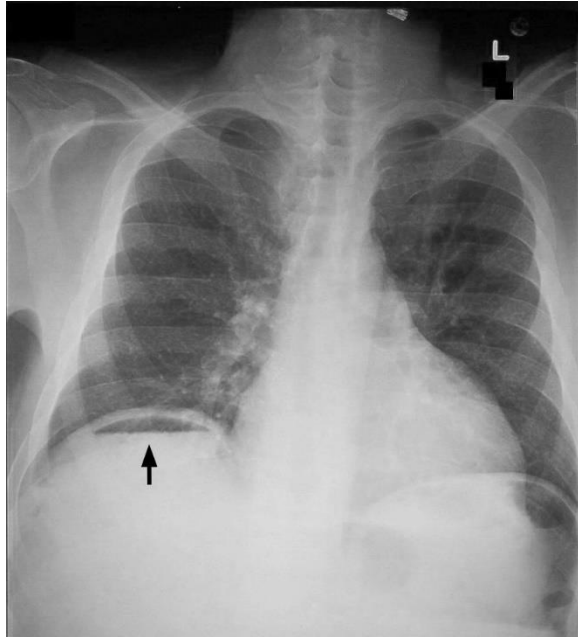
erect chest x-ray showing air under diaphragm (arrow).
